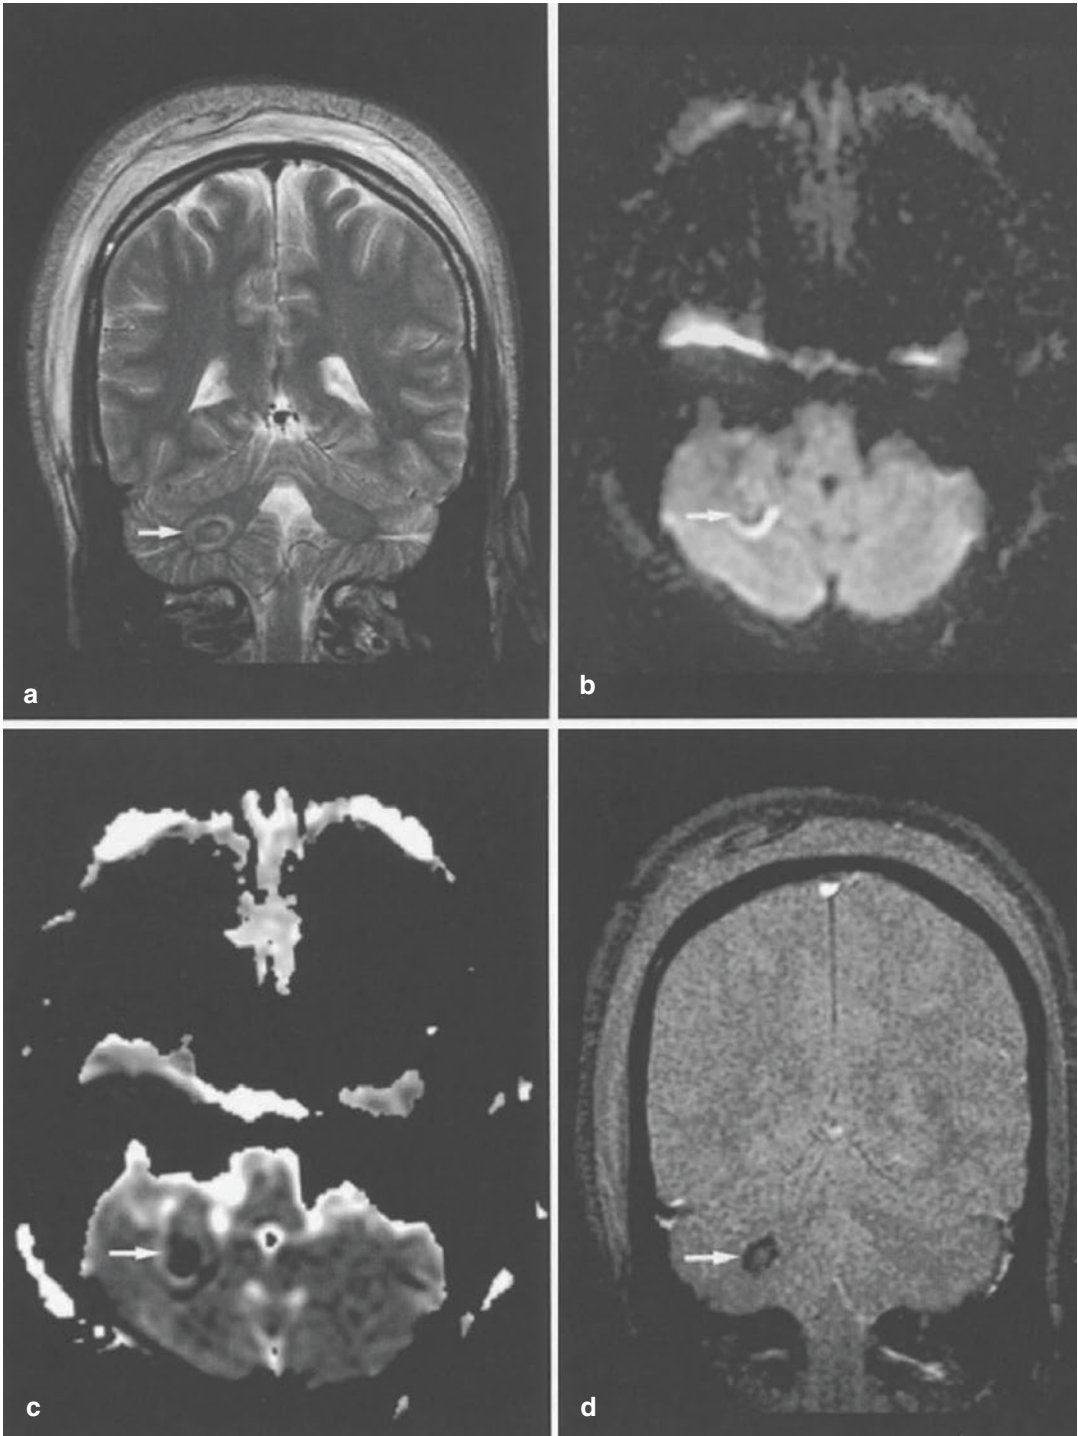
(a–d) Diffuse axonal injury in the cerebellum of an 18-year-old male patient after a motor vehicle accident. (a) T2-weighted image shows a hypointense lesion in the right middle cerebellar peduncle (*arrow*), (b) DWI image shows a hypointense lesion with a hyperintense
